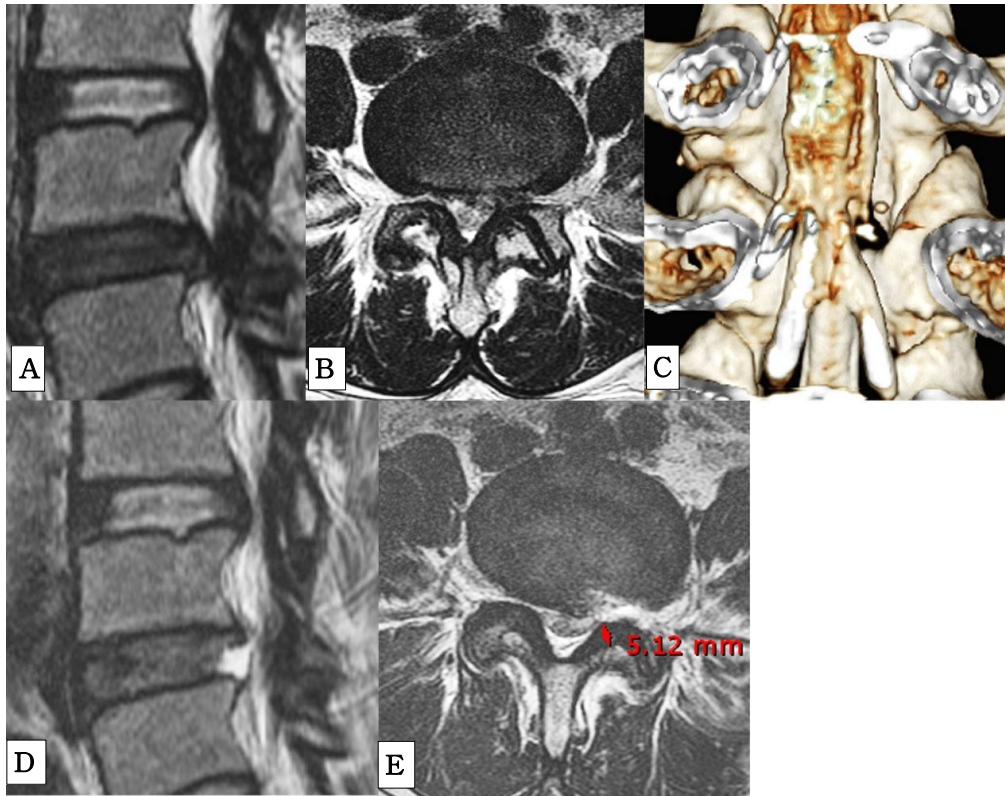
Preoperative MR images shows L4-5 disc herniation combined with spinal stenosis compressing the dominant root (A,B). Postoperative myelogram with 3D reconstruction CT shows decompressed traverse nerve root (C). Postoperative MR images shows herniated disc material successfully removed and nerve root decompressed at the lateral recess with thickened ligament flavum (>5 mm; D,E).
